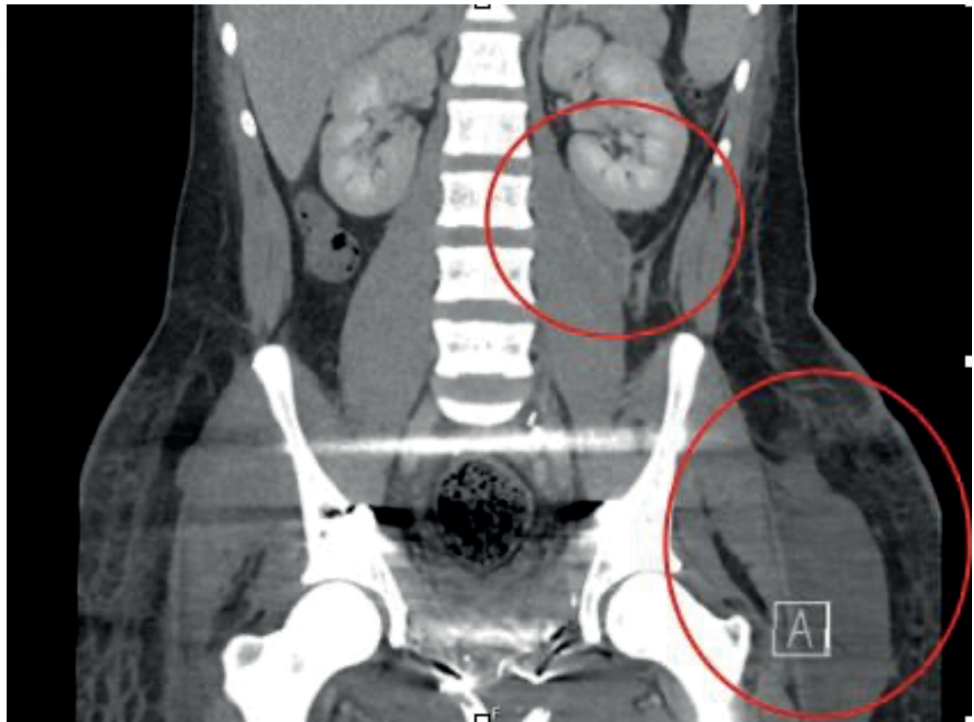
Coronal computed tomography view of lateral thigh collection and left psoas collection.
